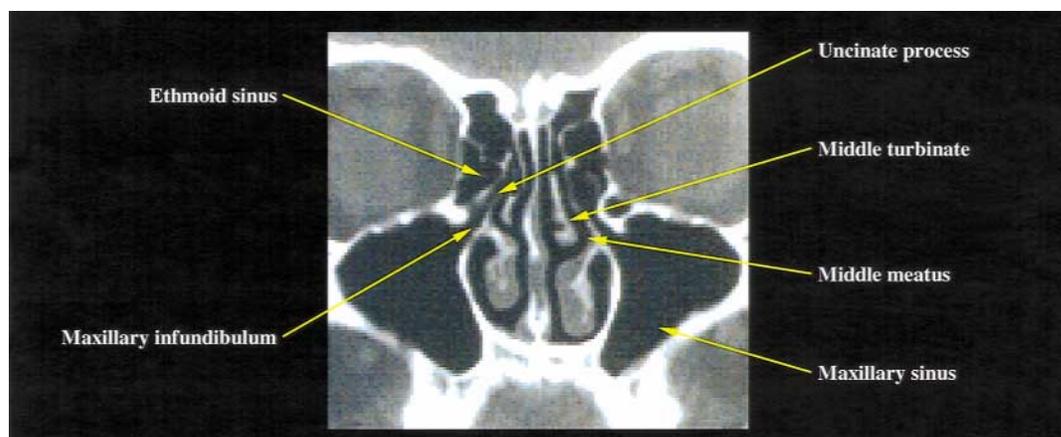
The normal anatomy of the OMU as seen on a limited sinus computed tomographic (CT) scan taken in the coronal projection.
